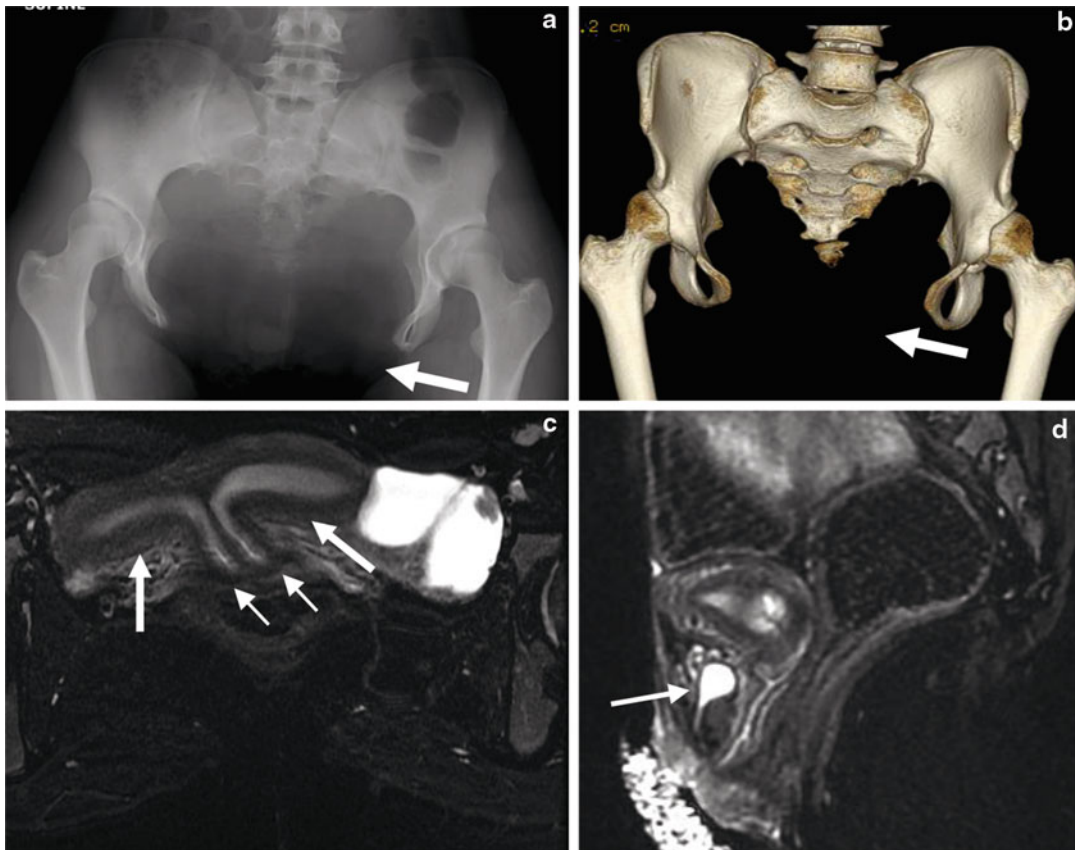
(a–d) A 16-year-old female was evaluated for previous history of bladder exstrophy. The pelvic radiography (a) and 3D CT reconstruction image (b) showed the previous site of bladder exstrophy with substantial widening of the pubic rami and ischium (arrows). MRI image (c) demonstrated uterus didelphys (large arrows) with vaginal duplication (small arrows). The structures in the pelvis (d) (the bladder (arrow), the uterus, and the rectum) appear more anterior on the perineum than normally expected. No past medical history was available (Courtesy of Dr. Grace Guo)
